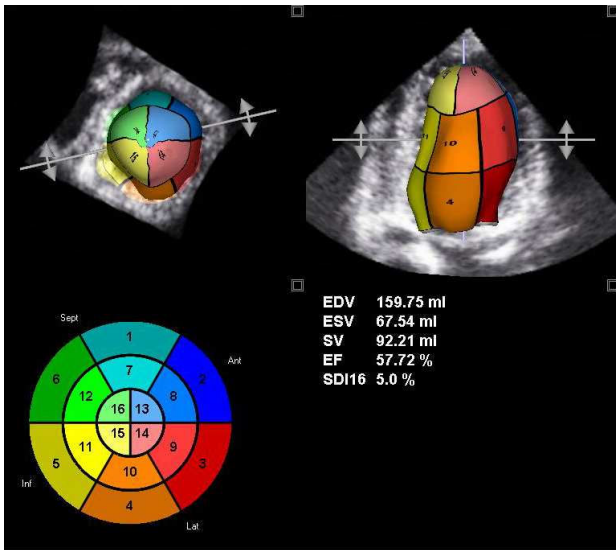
Tomtec 4D Volume Plug-in displays surface of LV boundary within the grayscale ultrasound data for confirmation of detected geometry. Global and segmental information is then displayed for review.
